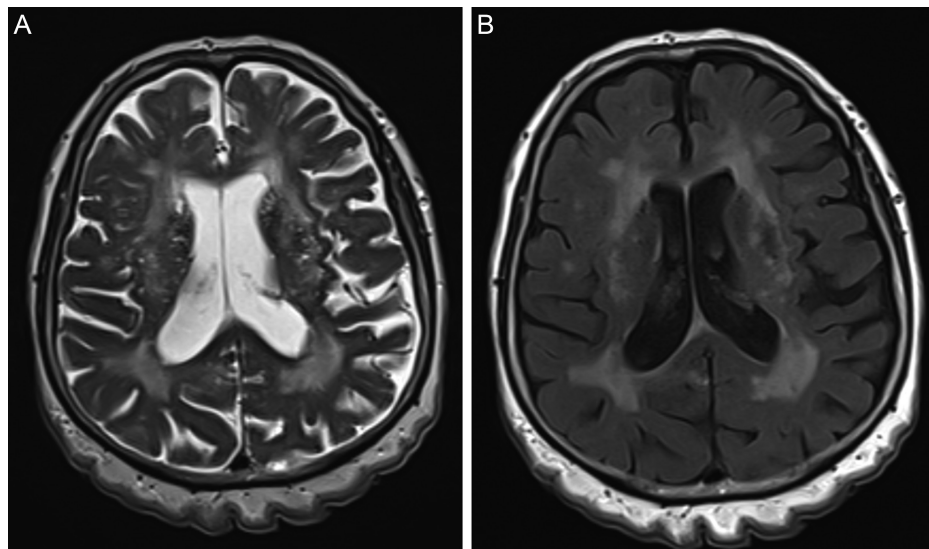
Axial T1- and T2-weighted magnetic resonance images show small vessel plaques associated with cutis verticis gyrata.
